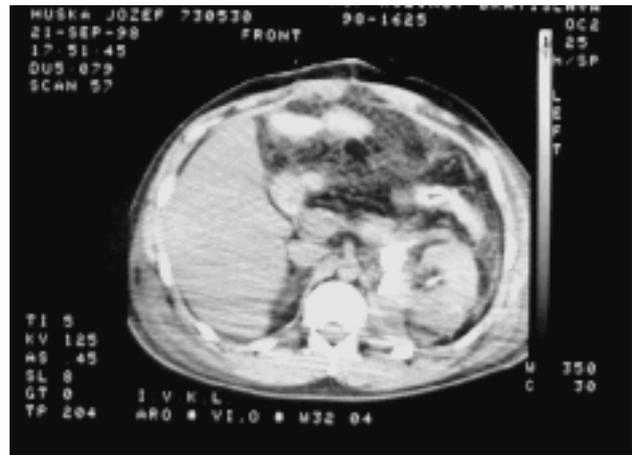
CT of the first patient after operation.
